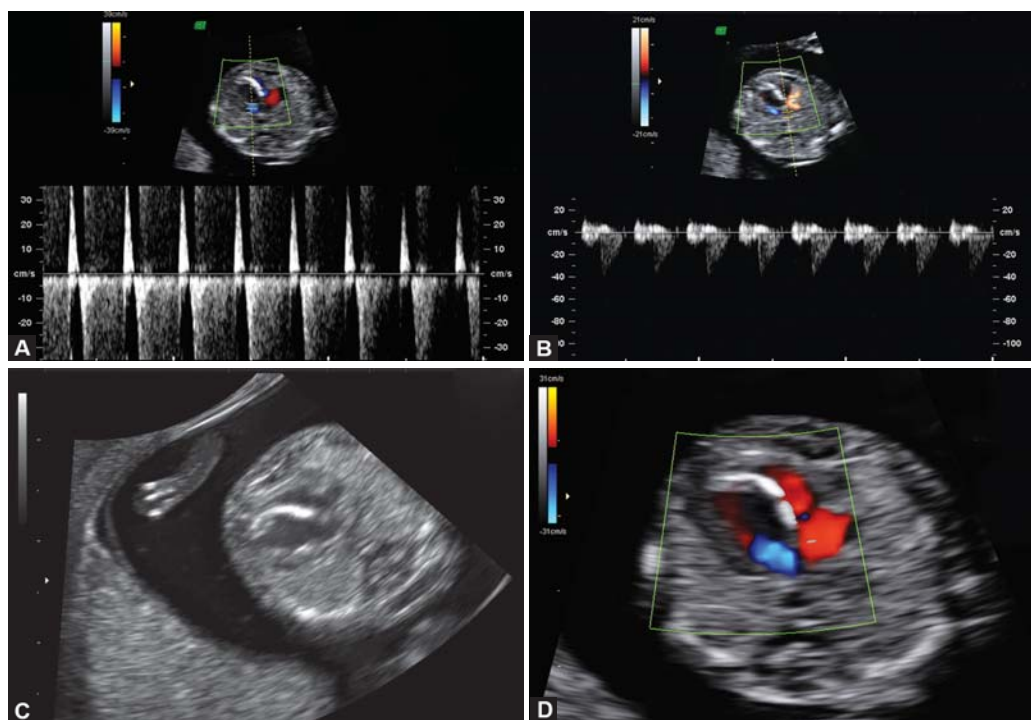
to E: Hypoplastic left heart at 14 weeks' gestation. *Note:* The identification of markers of CHD: increased nuchal translucency (A) and abnormal ductus venosus flow (B). Reverse flow at the 3 vessels view (C), hypoplastic left ventricle with reverse flow with color Doppler (D), reversed flow in aortic arch (E)
